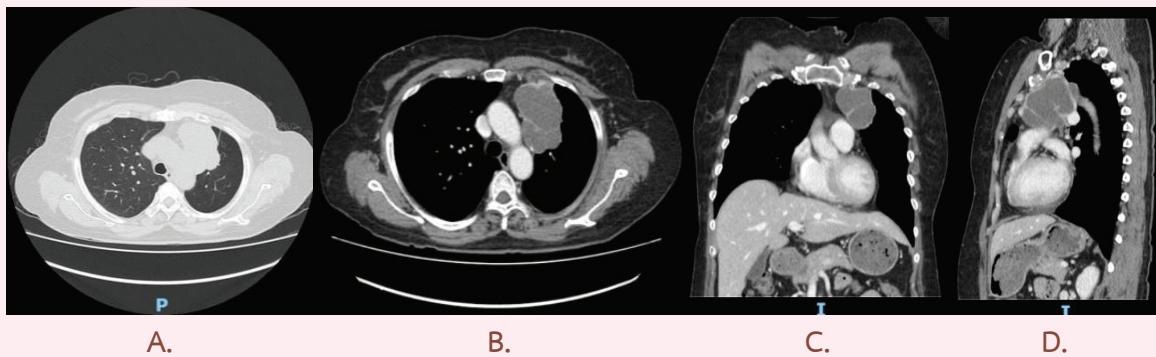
Appearance of Computer X-ray A. Axial view with lung window, B. Axial view with contrast, C. Coronal view, D. Sagittal view
